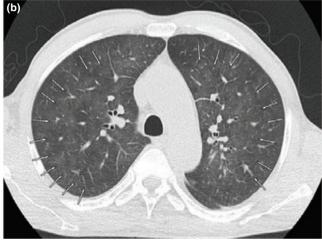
Clinical parameters and CT scan. (a) The course of fever, CRP levels, mycophenolic acid dose and antibiotic treatment during the hospital stay are shown. (b) Representative computed tomography of the chest, axial orientation, 64 slice-CT scanner (slice thickness 3 mm, collimation 2.4 mm). In the lung window, areas of ground glass opacity were found in the central areas of both lungs (arrows), sparing the peripheral lung parts. These are specific signs for usual interstitial pneumonia, which may occur in some cases under immunosuppressive therapy.
